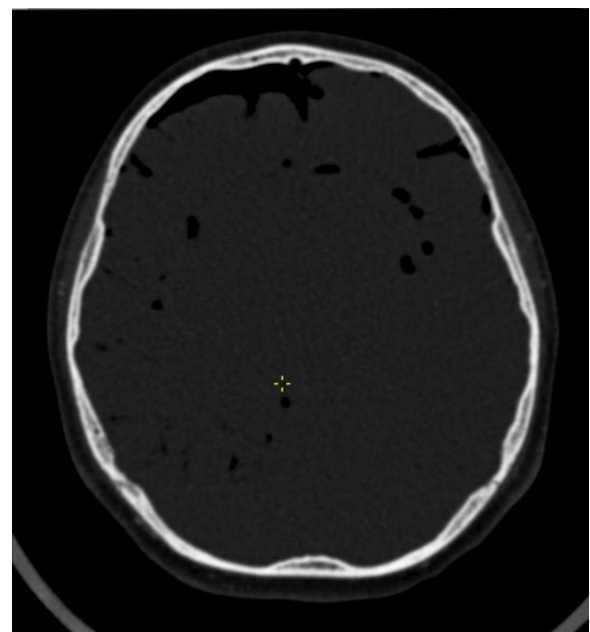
Follow-up bone window images of enhanced cranial CT. Extra- and intraaxial air densities, more prominent on the right with bilateral intra-axial air densities
